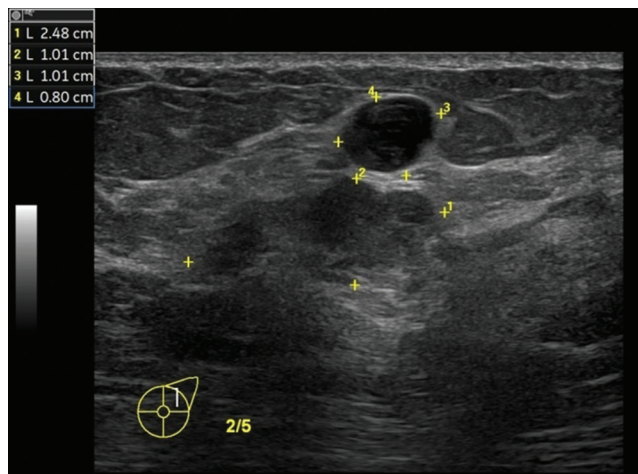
Breast ultrasound showing rapidly enlarged hypoechoic nodule at left 2/5. The size progressed with peripheral cystic change
